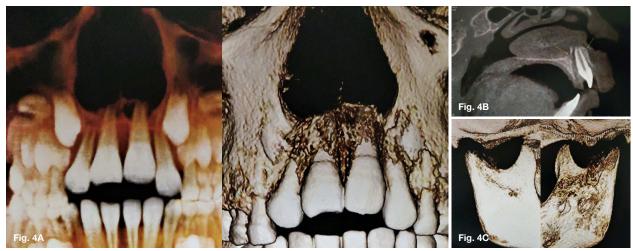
Case 1 - Pretreatment CBCT scan showing intrusion in nasal cavity and right subcondylar fracture.
